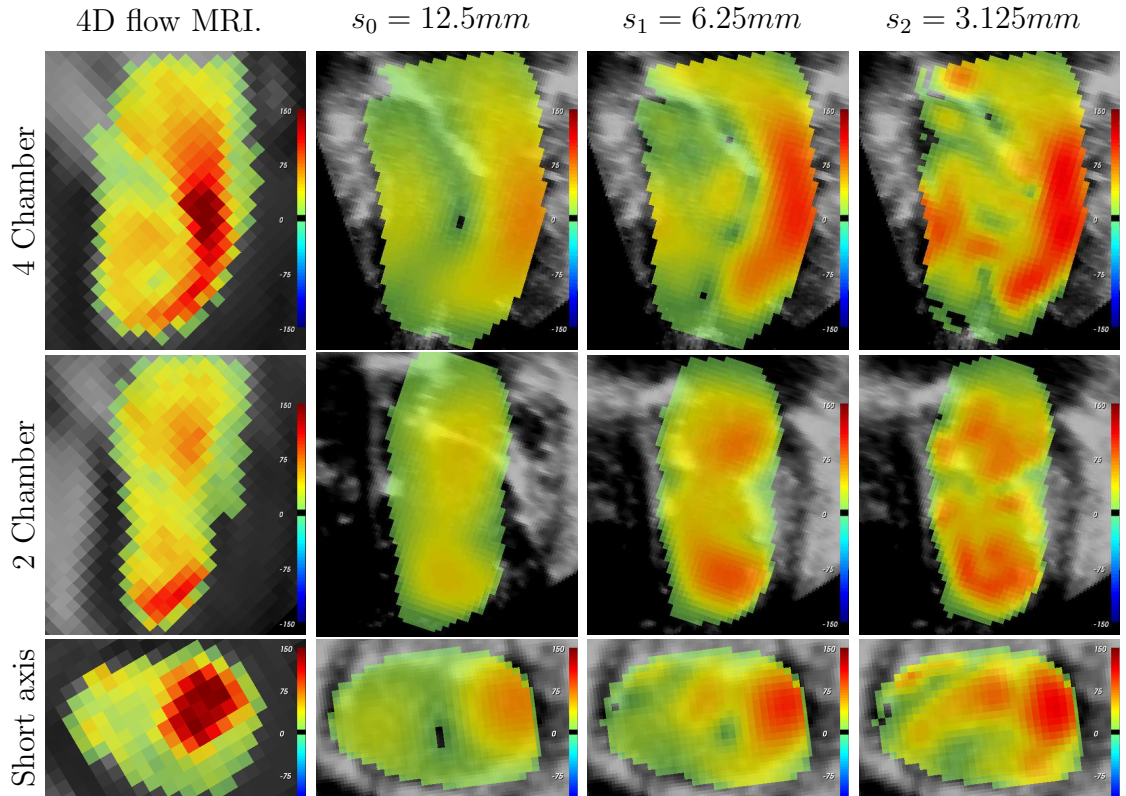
Comparison between 3 cross sectional slices of the velocity magnitude, from 4D flow MRI (first column) and the proposed method at three different scales. In all cases the colourmap codes velocity between 0 and 150 cm/s.
